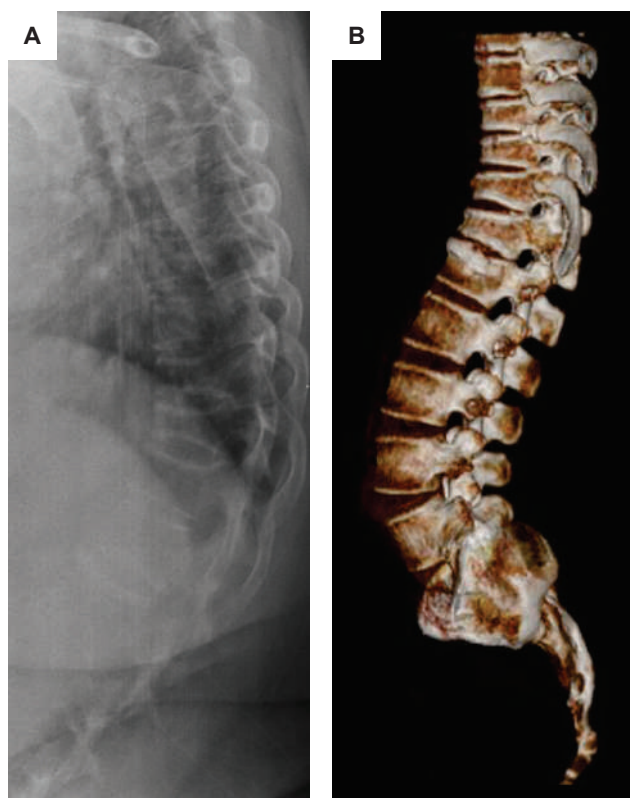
(A) Lateral view of thoracolumbar X-ray showing the compression fracture at T9 to L1 spine with osteopenic bone; (B) Volumetric 3D reconstruction of the thoracolumbar spine from CT images showing compression fracture.
